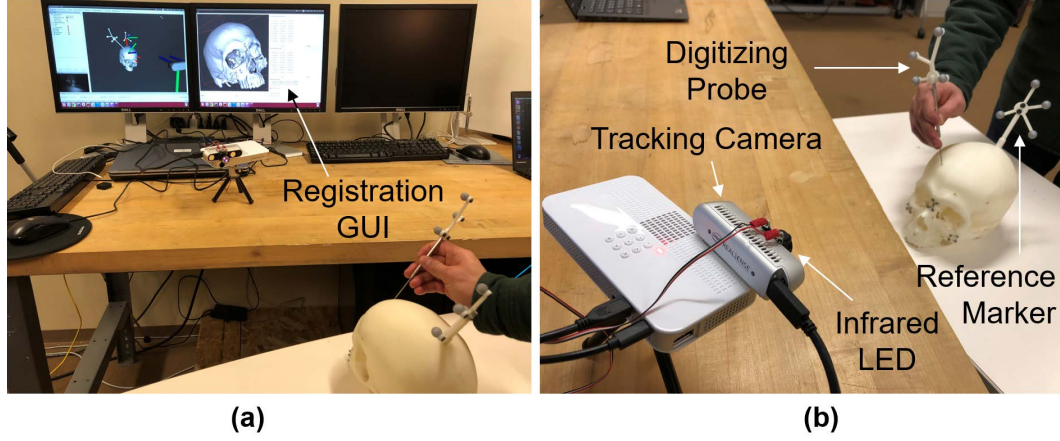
Patient-to-CT registration User used a digitizer probe to contact anatomical points to register the skull model from the patient space to CT space.
